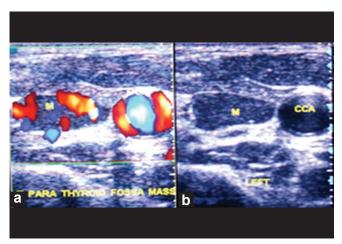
Parathyroid adenoma (M) detected by neck ultrasound. Note the oval shape, high vascularity (a) and hypoechoic appearance (b)
